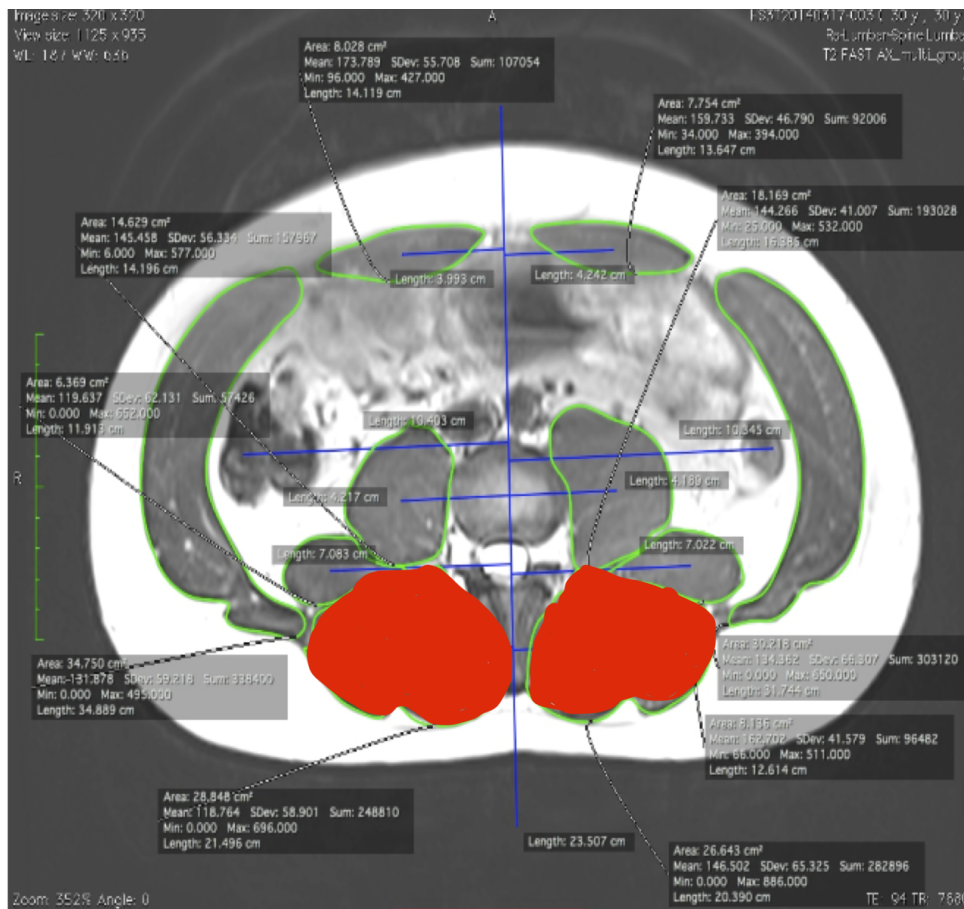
MRI Axial View of the Erector Spinae Muscles
